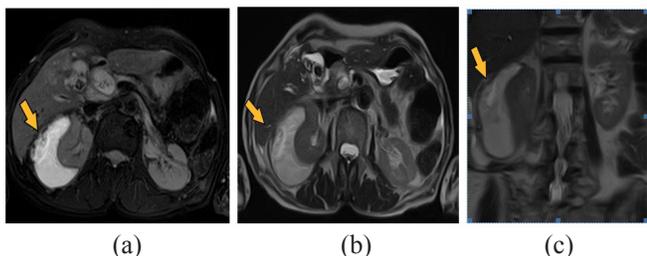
Native MRI of the abdominal cavity and retroperitoneal space (multiplanar reconstructions) of a 62-year-old patient on Day 4 after trauma: subcapsular hematoma in the upper, middle, and lower third of the right kidney (arrows).
